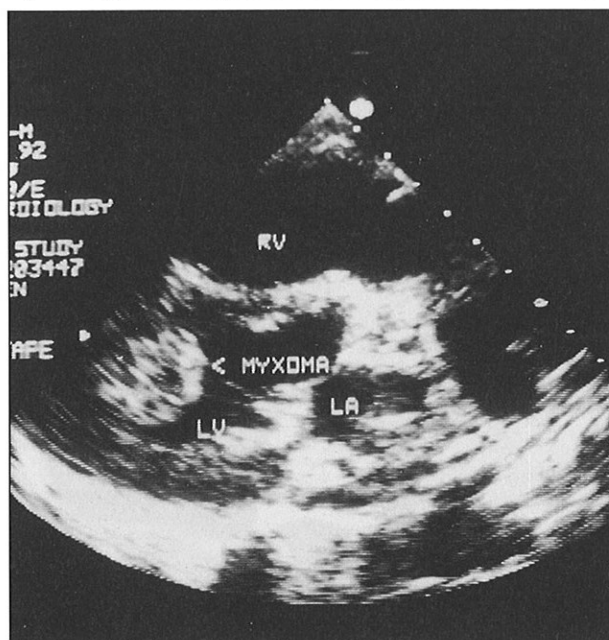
Cross sectional echocardiography showing a mass lesion protruding into the left ventricle (arrow). (RV = right ventricle, LA = left atrium, LV = left ventricle)
